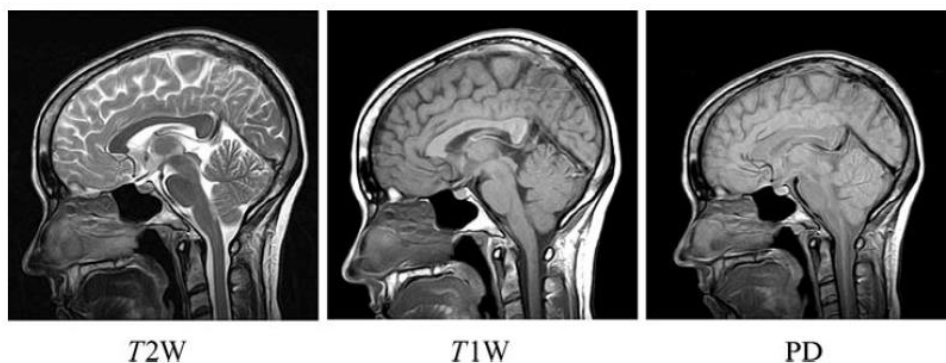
MR images of sagittal brain cross section (T2W – T2 weighted, T1W – T1 weighted, PD – proton density) [19]
